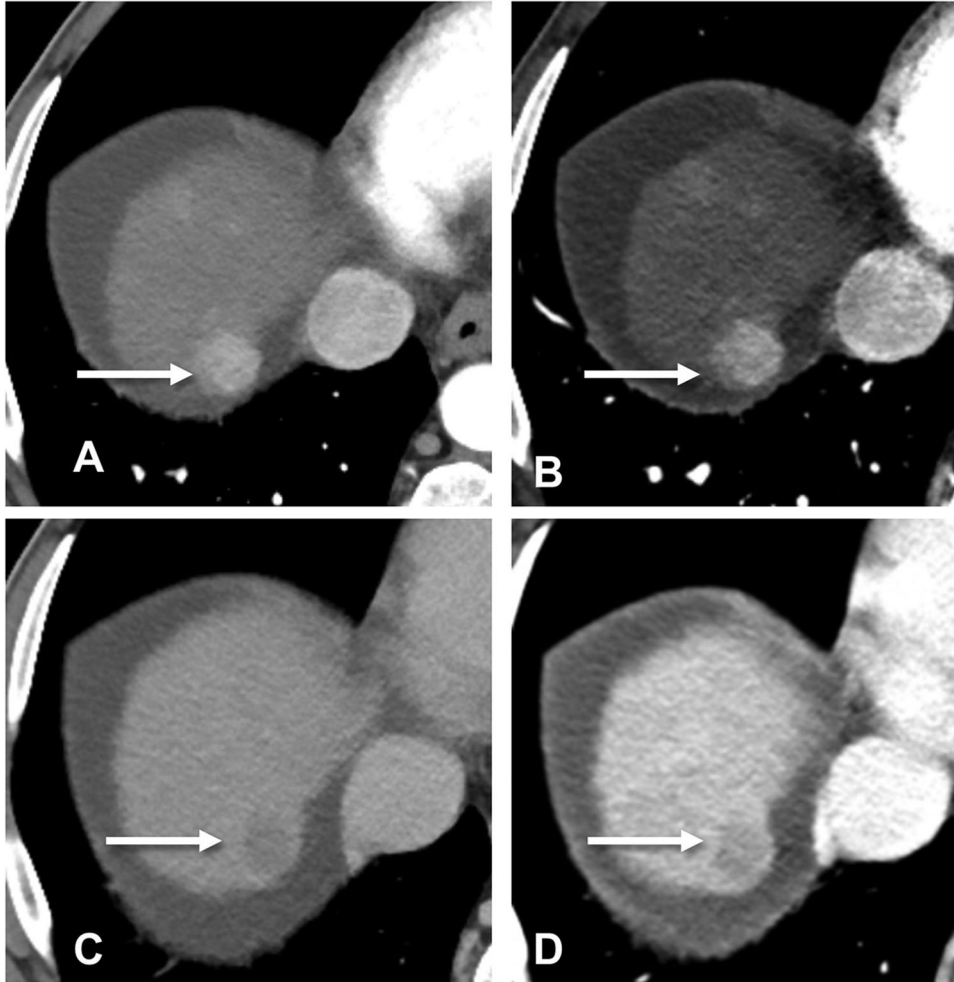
Dual-energy computed tomography demonstrating a hepatocellular carcinoma with arterial phase hyperenhancement on 0.6 linear blend (A) and 50 keV (B) imaging. The hepatocellular carcinoma also demonstrates washout on delayed linear blend (C) and 50 keV (D) images. (Images courtesy of Dr. Joel G. Fletcher, Radiology, Mayo Clinic, Rochester, MN, USA.)
